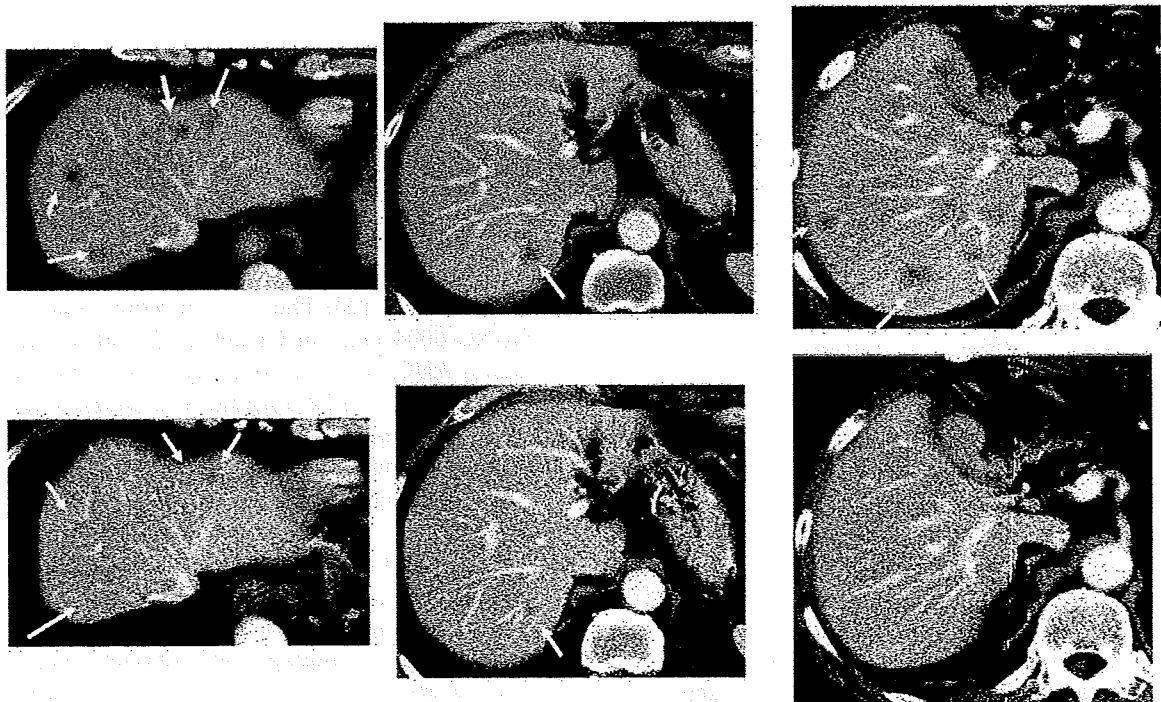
Serial computed tomography (CT) scans. A 60-year-old male with pancreatic cancer, who was treated with NK105 at a dose level of 150 mg/m². Baseline scan (upper panels) showing multiple metastasis in the liver. Partial response, characterized by a more than 90% decrease in the size of the liver metastasis (lower panels) compared with the baseline scan. The anti-tumor response was maintained for nearly 1 year (13).
